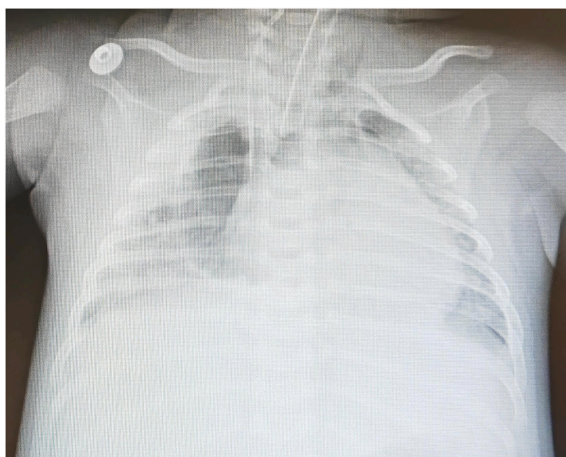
Chest X-ray before ECMO treatment.
